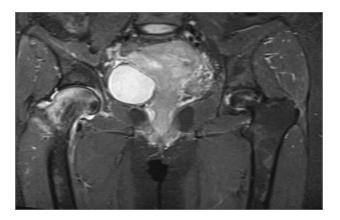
A MRI of the pelvic bones in case 3.
